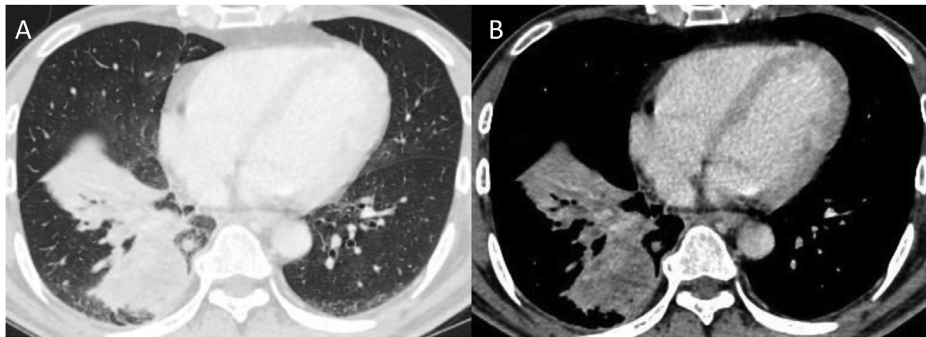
Chest computed tomography at the time of referral showed tumor and atelectasis of the right lung (A: lung window, B: mediastinal window).
